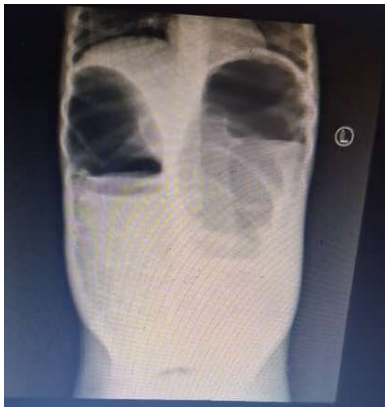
Abdominal x-ray showing significantly distended large bowel.
